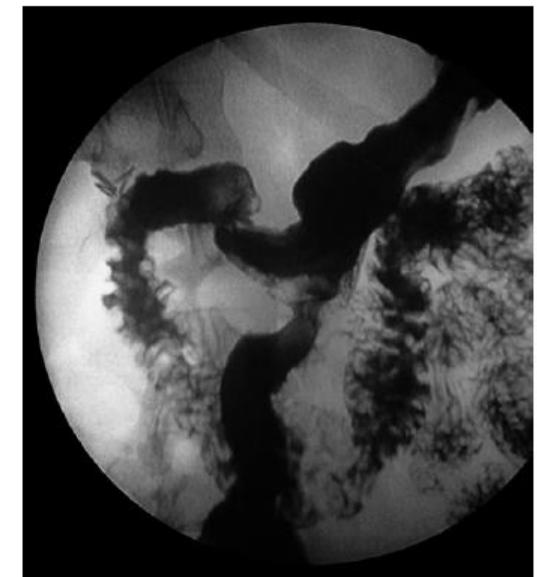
Late radiographic aspect of SG + TB. Observe that a part of the contrast media empties through the duodenum. The gastroileal anastomosis is very well shown.
